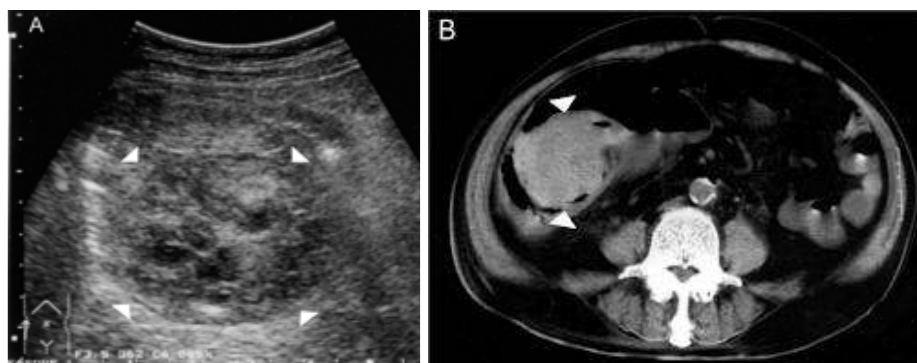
Ultrasound and abdominal CT scan revealed a circumferential caecal wall thickening
